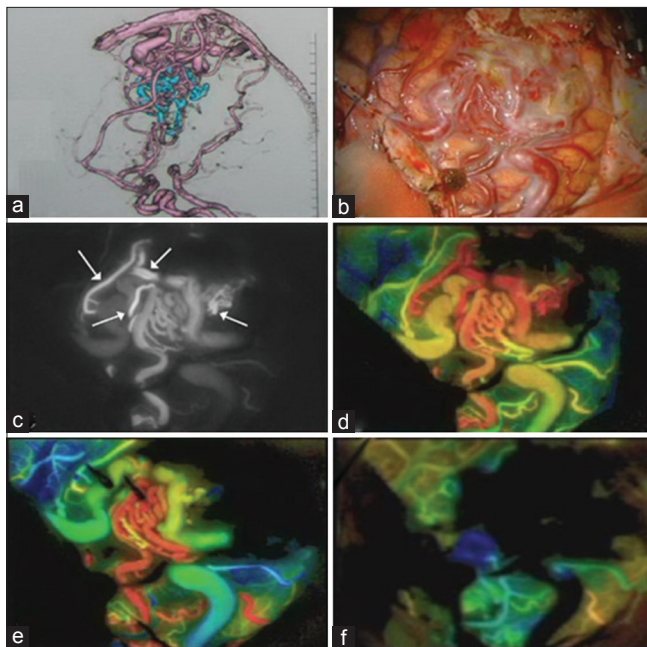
Right parietal arteriovenous malformation in a 55-year-old man. (a) Reconstructed computed tomography angiogram shows the location, feeding artery, and draining vein of the arteriovenous malformation. (b) After opening the dura, the lesion appears on the brain cortex. (c) Videangiography after indocyanine green injection immediately after dural opening. (d) Color-coded image after analysis of Figure 1c with FLOW 800. (e) Color-coded imaging after ablation of some feeding arteries. Note the color changes in the vessels indicating hemodynamic changes of the arteriovenous malformation. (f) Color-coded imaging after complete resection of the arteriovenous malformation confirming no remnant of the lesion
